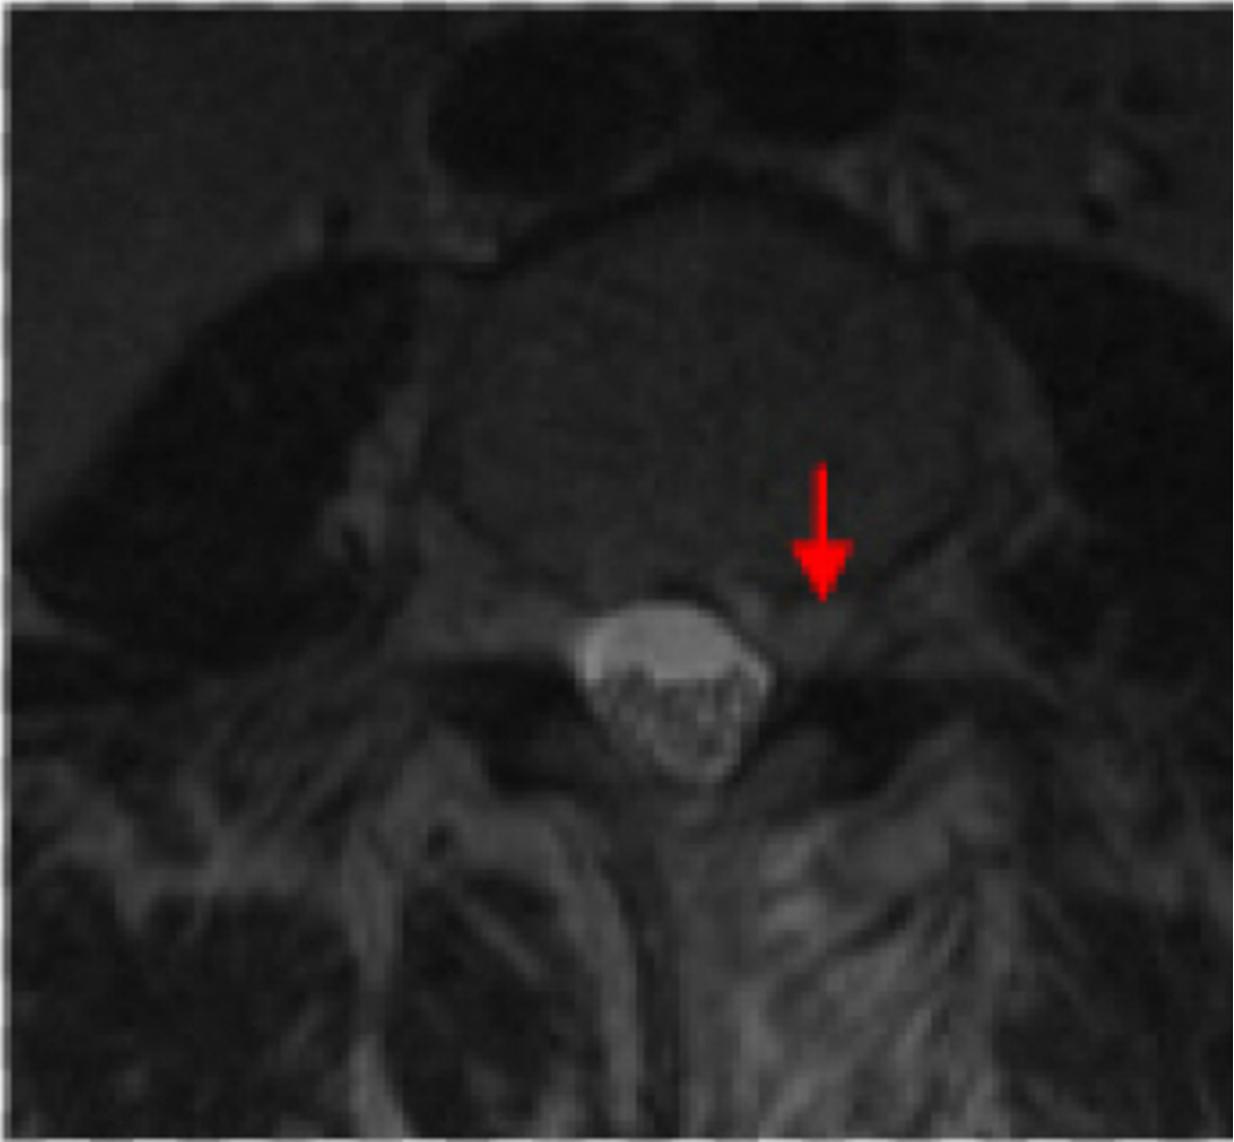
Axial T2 Weighted Lumbar Spine MRI image showing Sequestered Disc Fragment
